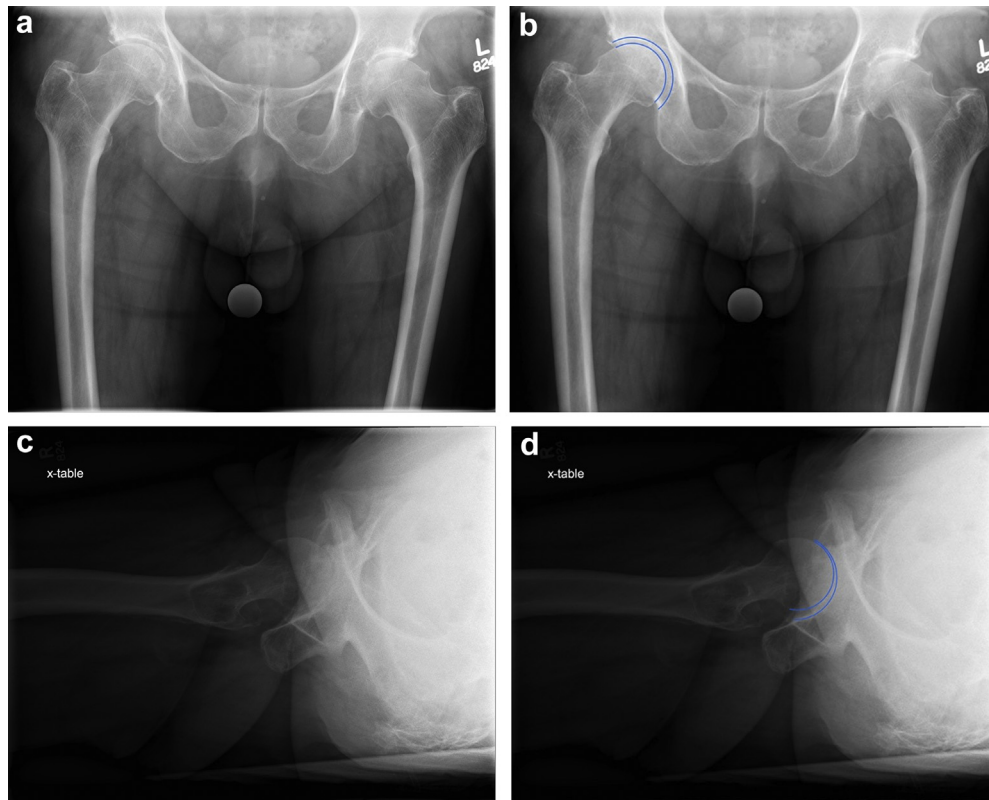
Anteroposterior (AP) low pelvis (a, unmarked; b, marked) and direct lateral (c, unmarked; d, marked) radiographs of a patient with hip osteoarthritis, demonstrating the significant anterior joint space narrowing apparent on the direct lateral, whereas not seen on the AP low pelvis. Blue lines denote the hip joint space.
